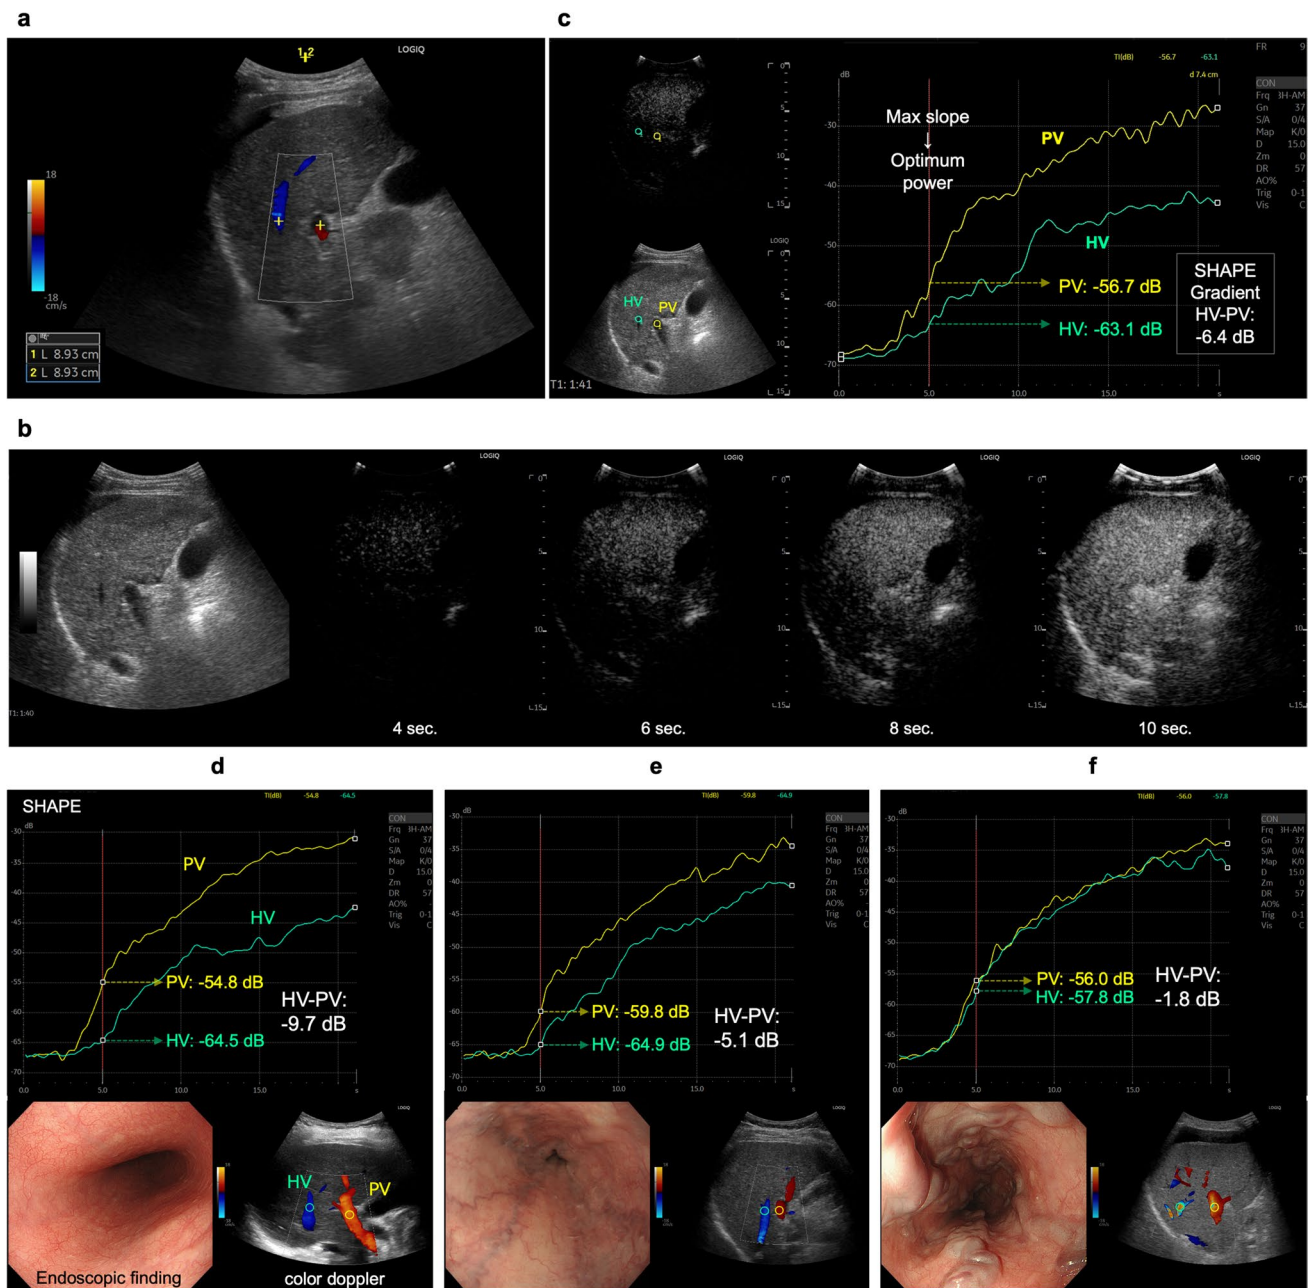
Identification of an ultrasound section that can simultaneously depict the right portal vein (PV) and hepatic vein (HV) at the same depth. a An image example of PV and HV identification using a color Doppler ultrasound examination. b Sample images of subharmonic contrast when the mechanical index is gradually increased. c An example of time intensity curve analysis, and the results for patients
